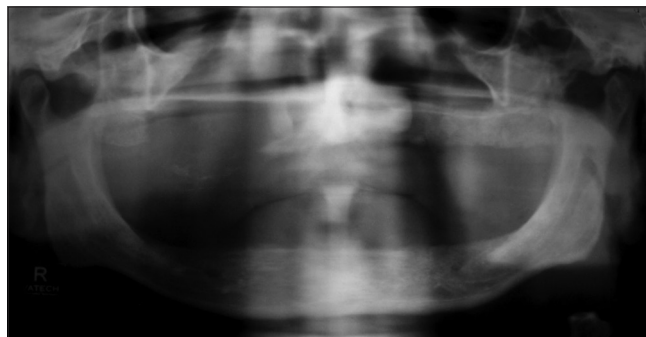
Panoramic radiograph showing well circumscribed radiolucency of right maxilla
